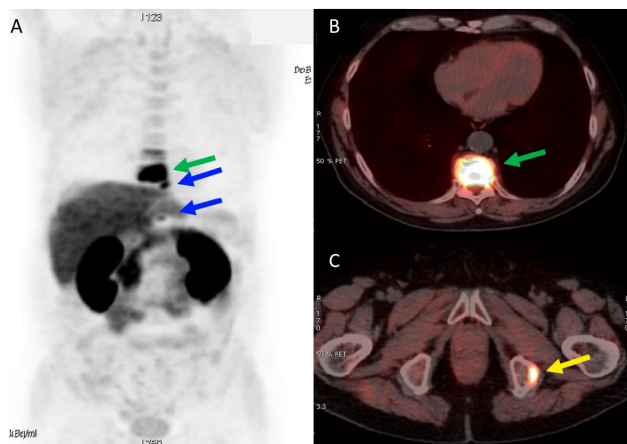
Sixty-four years old man submitted 6 years before to RT for PC Gleason 7. He performed ¹⁸F-FCH PET/CT because of PSA levels of 2.56 ng/dL. MIP (A) and fused images (B, C) showed multiple bone lesions such as in D10 vertebra (SUV_{max}: 23.5, green arrow), D9 and D12 vertebrae (blue arrows) and left ischium (SUV_{max}: 20.1, yellow arrow)
